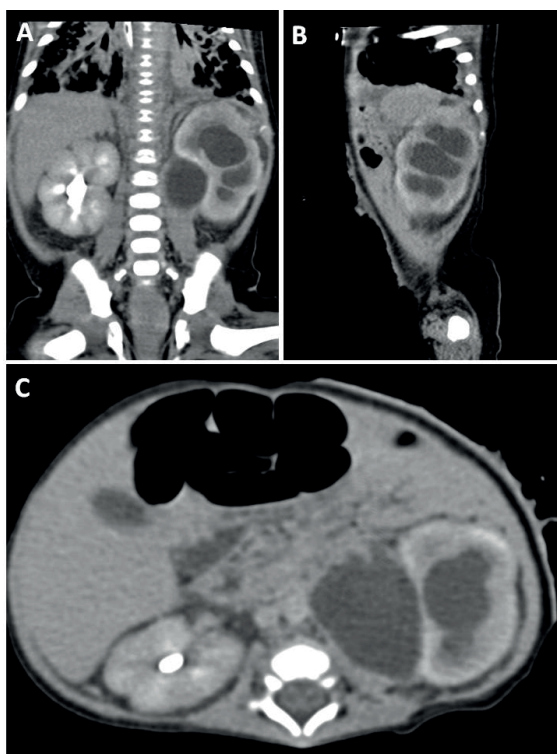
Computed tomography at the time of diagnosis suggestive of stenosis of the left pyeloureteral junction, which is associated with the presence of renal abscesses.
